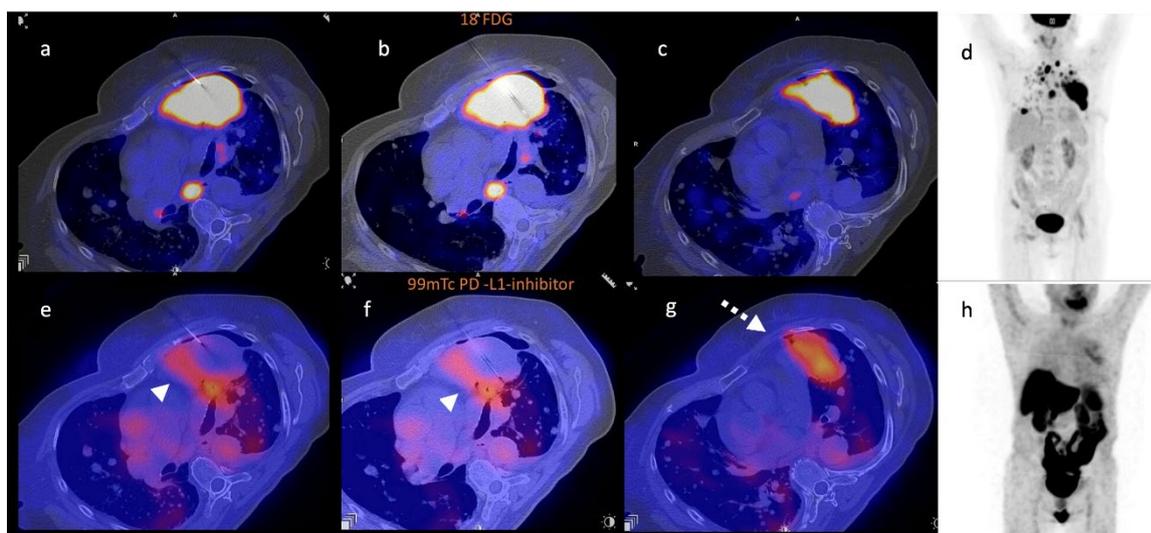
A 70-year-old woman diagnosed with poorly differentiated lung adenocarcinoma, mutated EGFR (exon 19 deletion) and IHC for PD-L1 with negative results. [^{18}F]FDG PET/CT guided biopsy with distal end of coaxial needle in solid and hypermetabolic portions of left lung tumour (a-b). Retrospective co-registration of the inhibitor directed at PD-L1 (technetium-99m SPECT/CT) with the CT used for the biopsy, in which an absence of radiotracer concentration is observed at the biopsy sites (e-f). The expression of PD-L1 is heterogenous, dynamic and is not necessarily related to hypermetabolism, in such a way that the low immunoreactivity could be related to a failure in sampling and not to the real behaviour of the tumour, because the portion with greater reactivity is found in the medial peripheral (head arrow) and caudal portion of the tumour (g) (dotted arrow).
